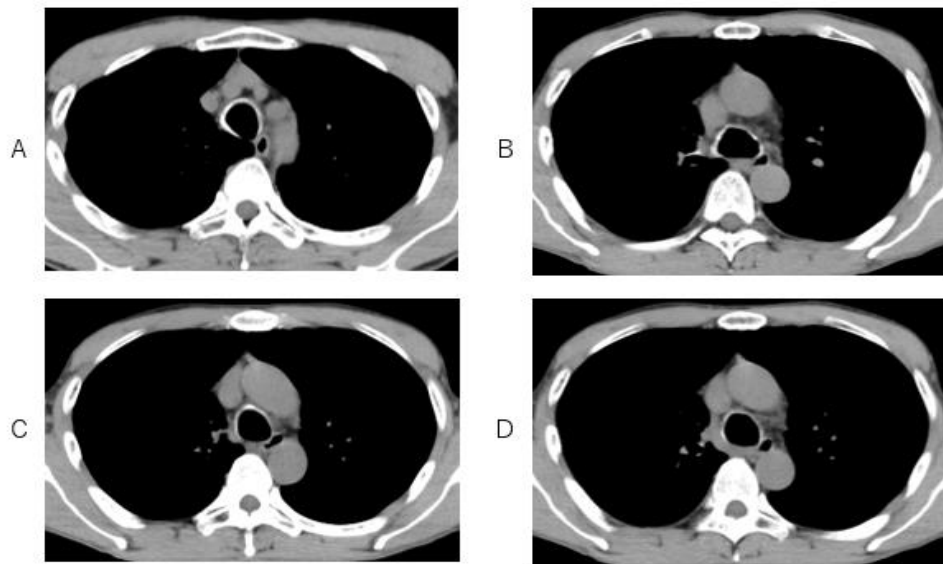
Bronchial cartilages are incorporated at the anterior and lateral bronchial wall but not at posterior bronchial wall on chest CT with mediastinal level.
